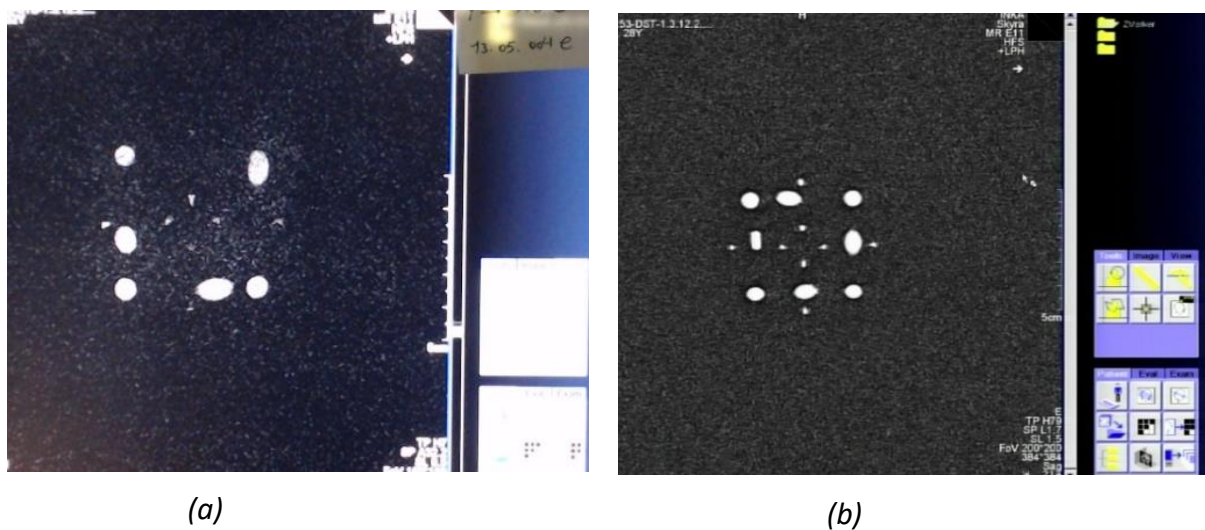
Setup configuration of the image acquisition procedure in the MRI control room.*
